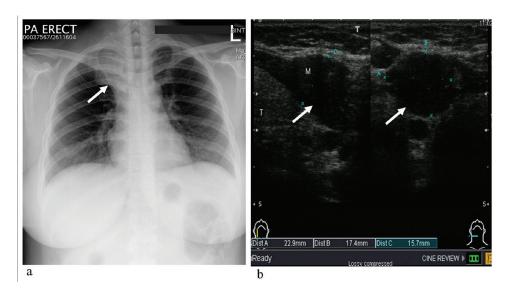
(a) Frontal chest radiograph showing an enlarged mediastinum; (b) Ultrasound examination demonstrating a superficial cystic lesion measuring 22.9 mm x 17.4 mm on the right side at the base of the neck
